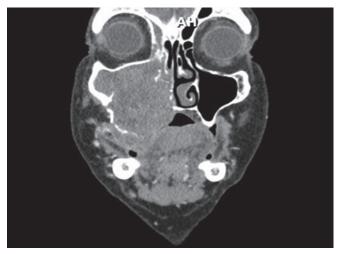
Coronal view CT face with 6.8 cm mass in the right maxilla and maxillary sinus
